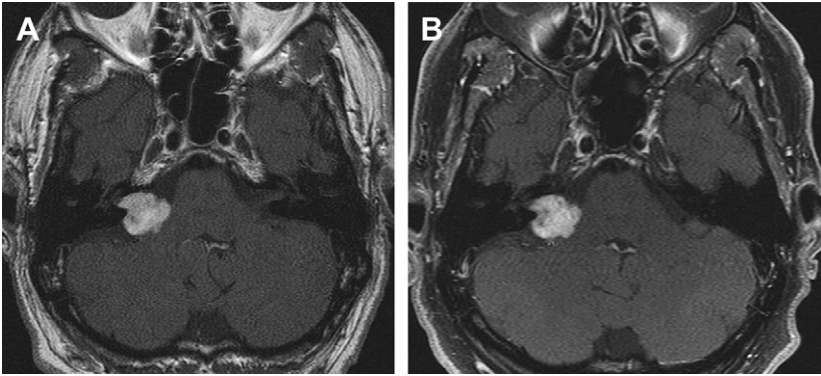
(A) Axial T1 weighted gadolinium-enhanced MRI of a right-sided vestibular schwannoma before Cyberknife radiosurgery. (B) Follow-up axial T1 weighted gadolinium-enhanced MRI taken 6 years after Cyberknife radiosurgery demonstrating no evidence of tumor progression.
